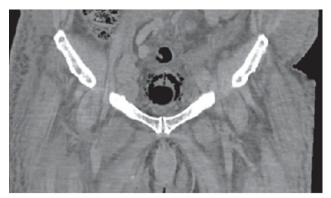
Uro-CT in anterior sagittal section evidencing a vesicle reduced in size, with thickening of its walls and perivesical gas.
